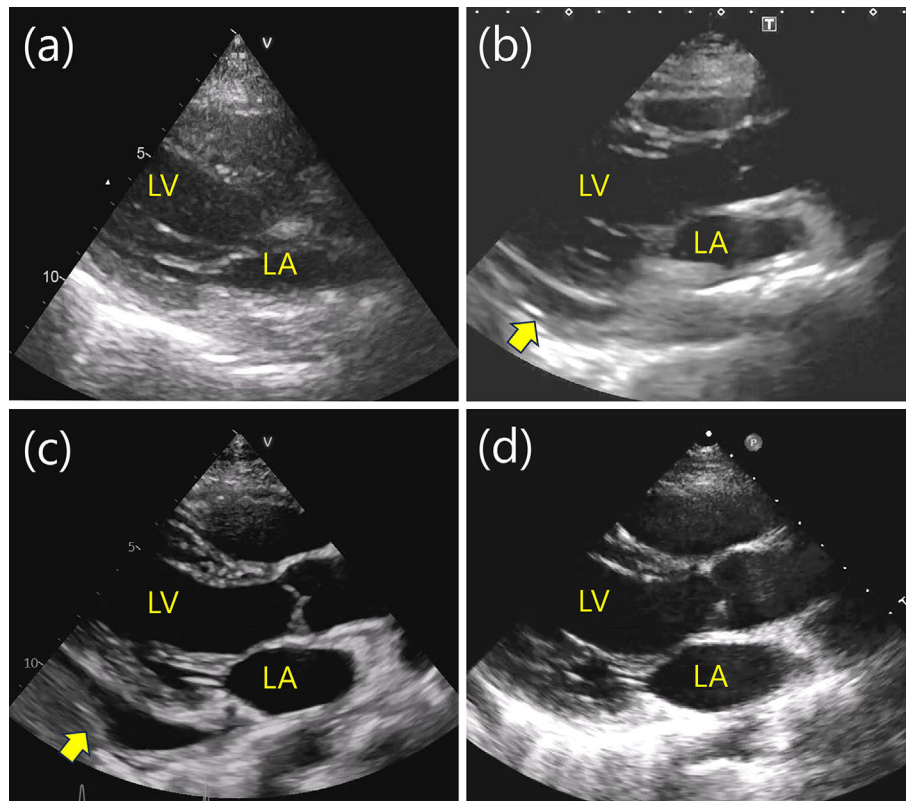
Echocardiography at end-diastole on (a) day 1, (b) day 3, (c) day 10, and (d) day 18. (a) No pericardial effusion or left ventricular wall motion abnormalities were observed on day 1. (b) On day 3, a newly developed pericardial effusion (arrow) and mild hypokinesis of the left ventricular wall were observed. (c) On day 10, despite treatment with prednisolone and hydroxychloroquine, the pericardial effusion (arrow) had increased. (d) On day 18, following anifrolumab administration, a marked reduction in pericardial effusion was observed.
